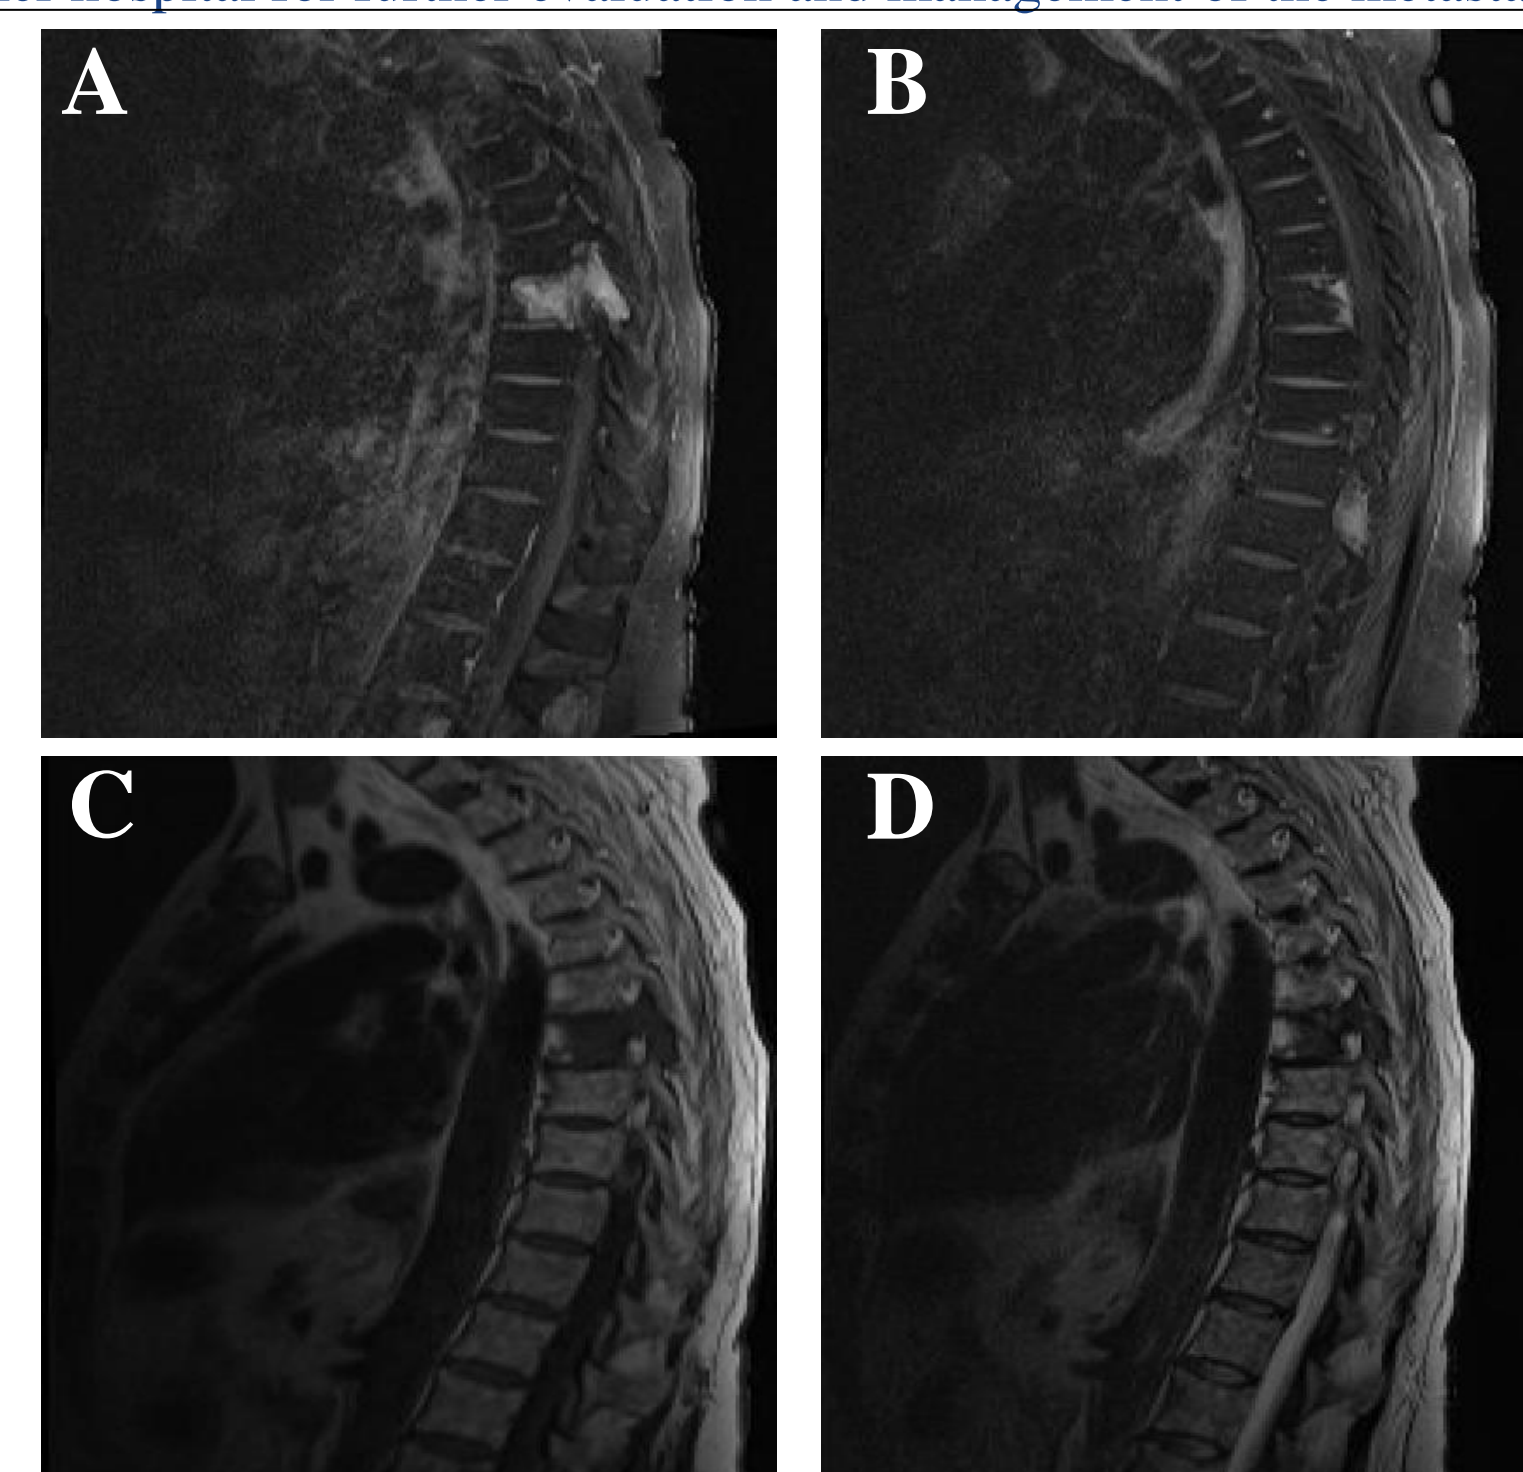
MRI imaging of the lumbar spine. A) Prominent T7 lesion seen on T2; B. Smaller portion of T7 lesion, as well as a Schmorl's node at T9 and bulky lesion between T11; C) Same T7 lesion, seen as hypodense on T1; D) Additional view of T7 and T11 lesion on T1.
